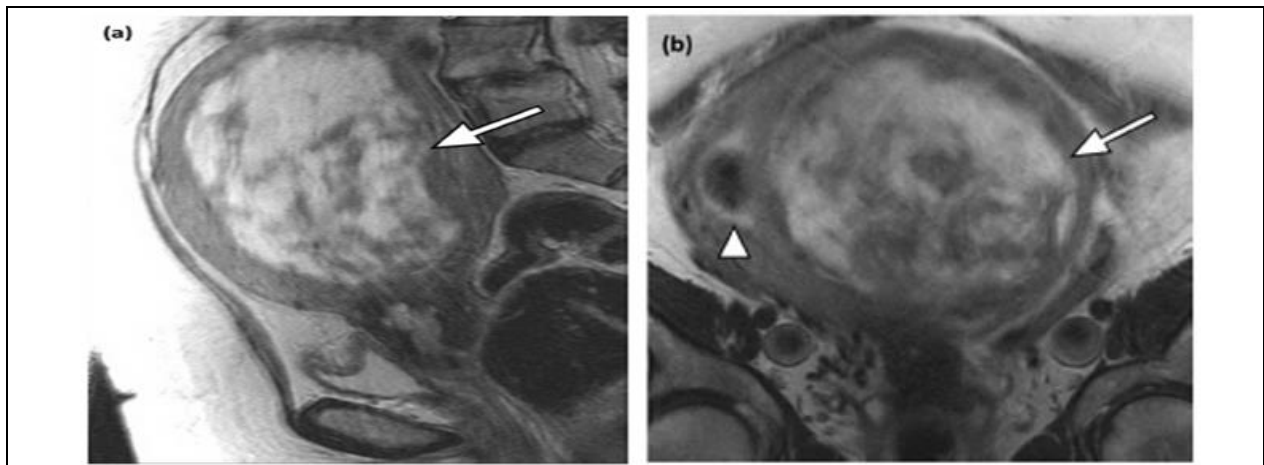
A leiomyoma is mischaracterized in a 47-year-old female patient. A leiomyosarcoma was suspected by the majority of readers (mean suspicion score: 3.3). a) A sagittal T2-weighted fast spin echo MR image of a leiomyoma; the arrow points to a dense mass that forms behind the heterogeneous inner uterine wall, b) On the coronal plane, there is a small submucosal leiomyoma with low signal intensity adjacent to a high signal intensity mass that is pressing down on the endometrial cavity (arrowhead)
